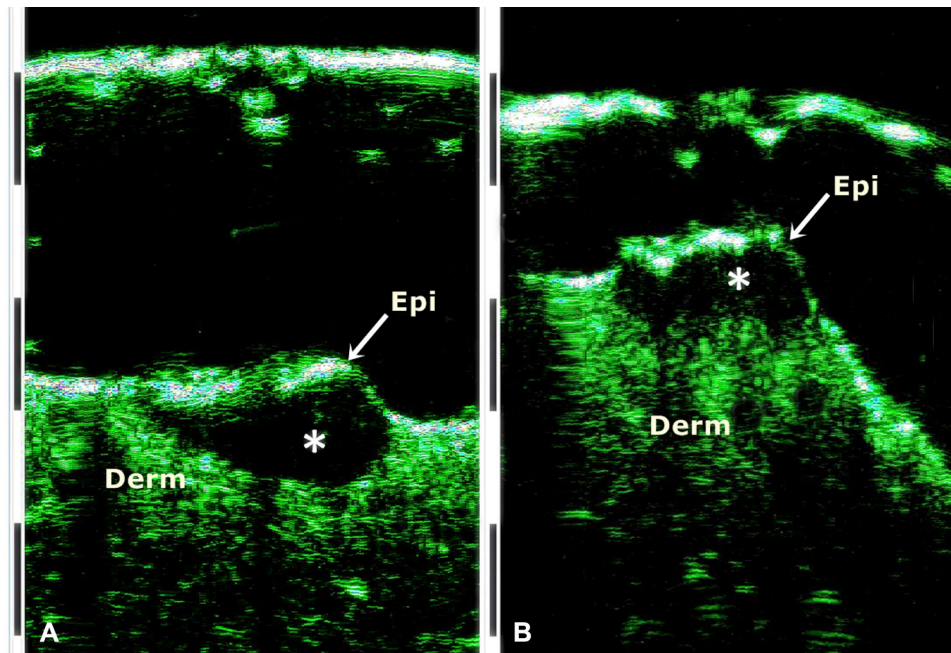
A, In vivo high-frequency ultrasound (HFUS) image of a nodular basal cell carcinoma (BCC); B, Ex vivo HFUS image of the same tumor. Note the different tumor shape obtain by ex vivo, well-demarcated hypoechoic tumor (*), epidermis (*Epi*), dermis (*Derm*), and the free surgical margins.
